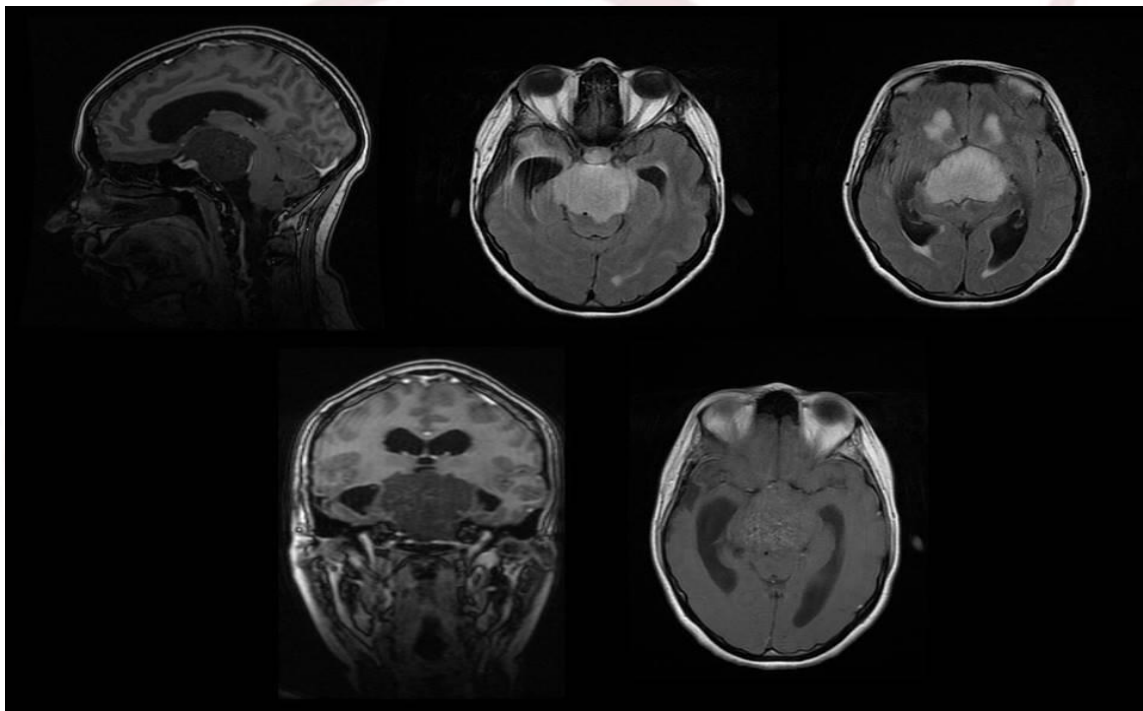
In T1 sagittal section, a massive, extra-axial, hypointense expansive formation with a mass effect is observed, located in the suprasellar region. In the FLAIR power, axial cuts, a lesion with a hypersignal is observed, which displaces and compresses the optic chiasm, hypothalamus and later the midbrain and bridge. In coronal section T1, tumoral lesion with hyposignal, of large dimensions, centered and suprasellar, which compresses the third ventricle, associated with hydrocephalus and diffuse deletion of the cortical grooves. Discrete and heterogeneous focal captures by means of contrast in the post-contrast image.
